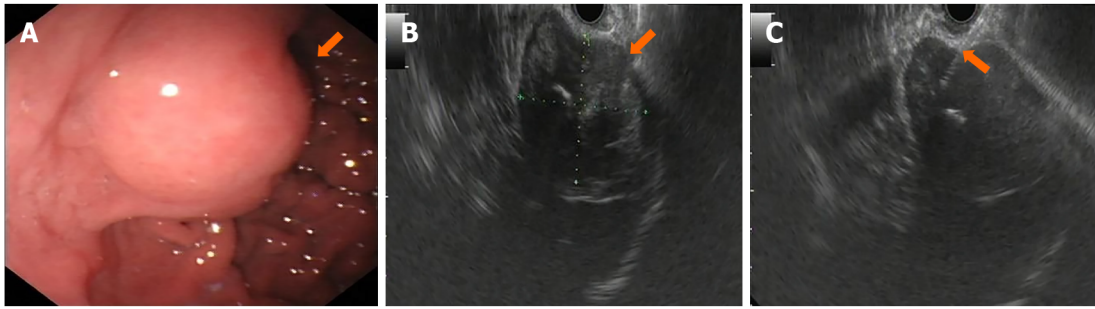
Mass was observed on the fundus of the stomach by endoscopy and endoscopic ultrasound. A: Endoscopy showed a smooth surface of the mass (orange arrow); B: Endoscopic ultrasonography showed a hypoechoic and heterogeneous mass, derived from mucous muscularis, with hyperechoic area (orange arrow); C: Endoscopic ultrasound guided fine needle aspiration. The bright line is the puncture needle (orange arrow).
